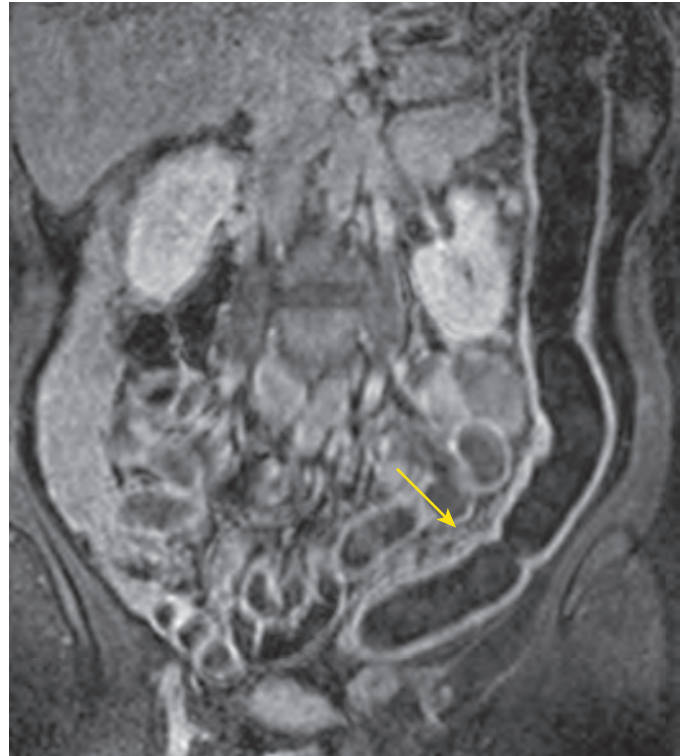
Ulcerative colitis: MR features. T1-weighted MR coronal image shows loss of haustration and hyperenhancement of mucosa of the left colon (arrow) in this patient with active ulcerative colitis. (Courtesy Shahid M. Hussain, MD.)
